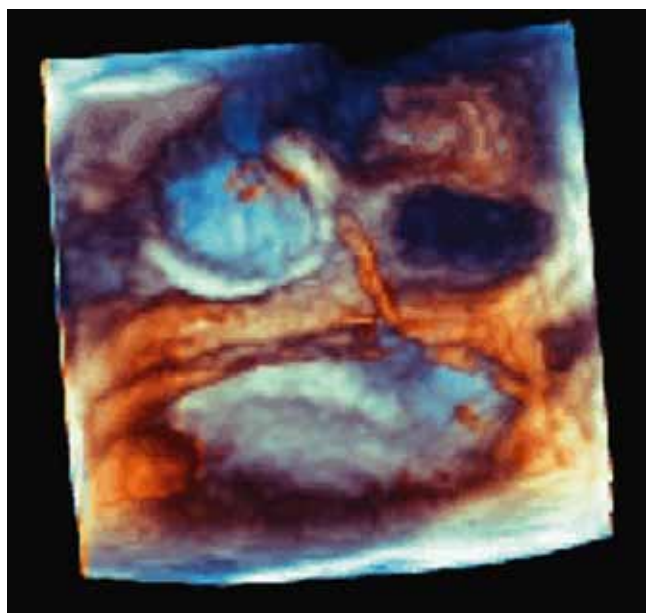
Three-dimensional echocardiogram of the left pulmonary veins with circular mapping catheter in the inferior pulmonary vein (left side). Dark structure on the right side corresponds to the left superior pulmonary vein. Ellipsoid structure in the lower part represents left atrial appendage.
